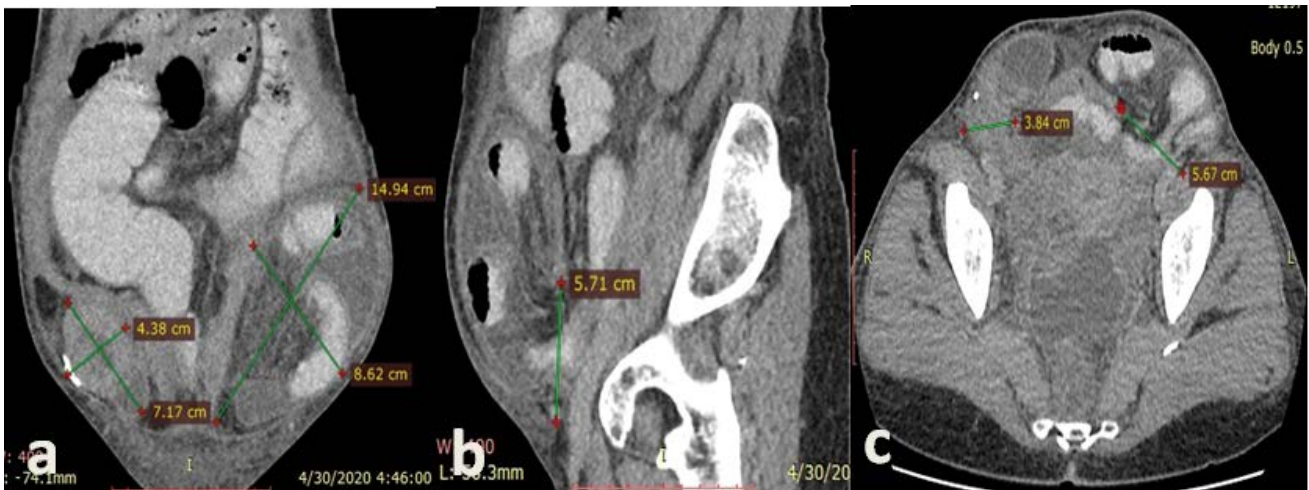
Contrast enhanced abdominal CT scan showing bilateral spigelian hernia: (a) Coronal view showing content of sacs. (b) Sagittal view showing size of defect of left spigelian hernia. (c) Axial view showing spigelian fascia defect of 5.7cm on the left and 3.7cm on the right
